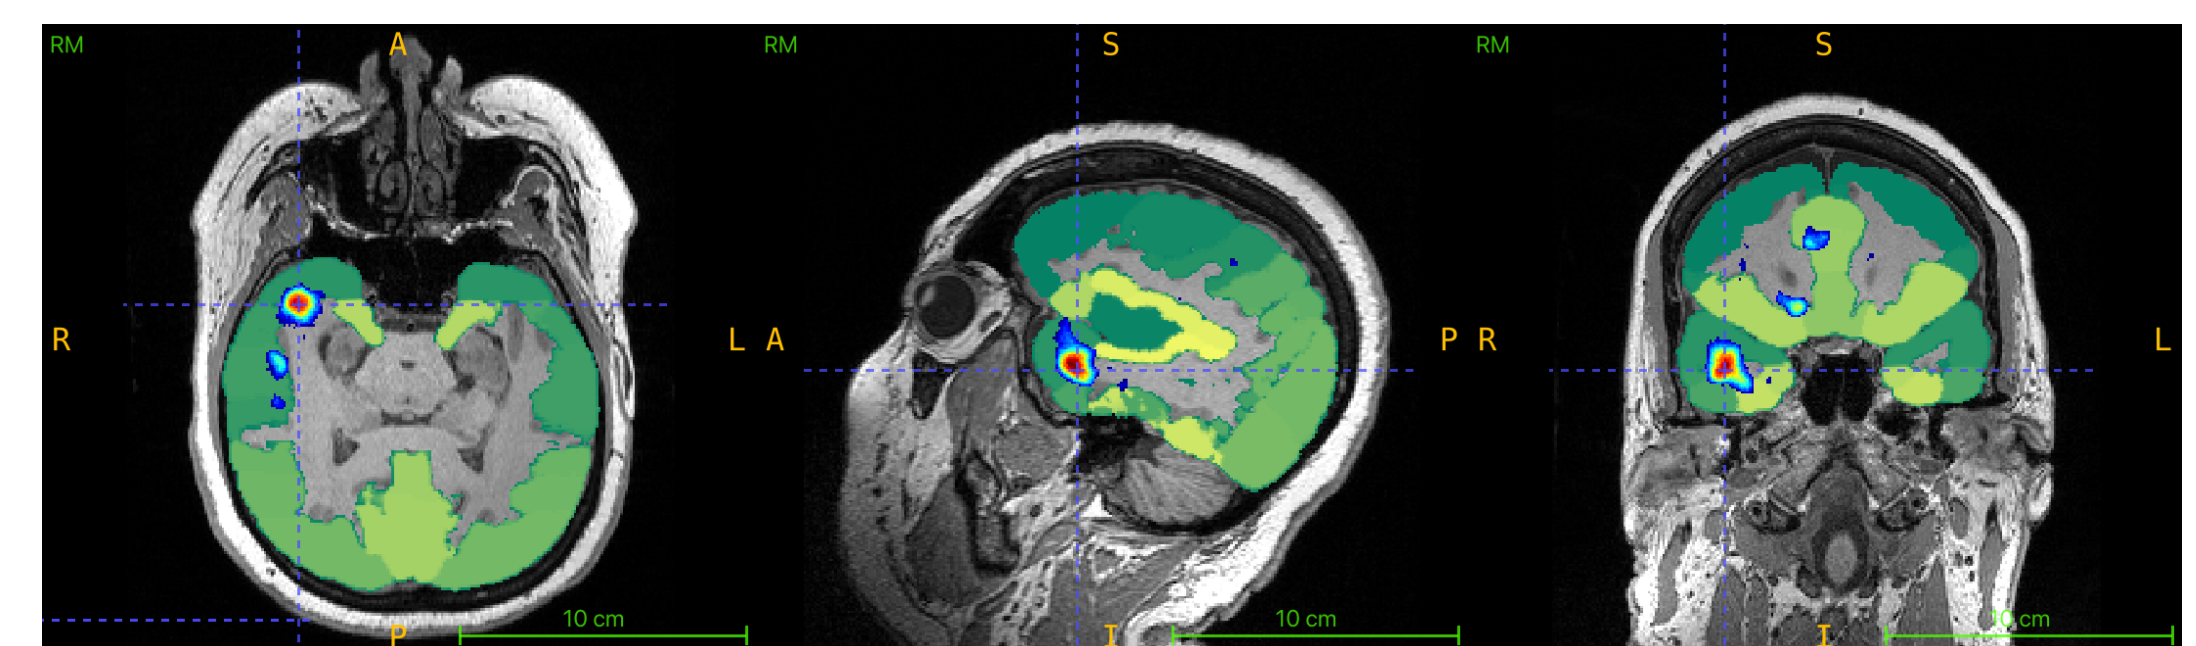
Localization of the epileptogenic focus on the MRI using the median normalization method, overlaid with the Harvard-Oxford cortical atlas in the subject's MRI space. The focus is identified in the right temporal pole region.
